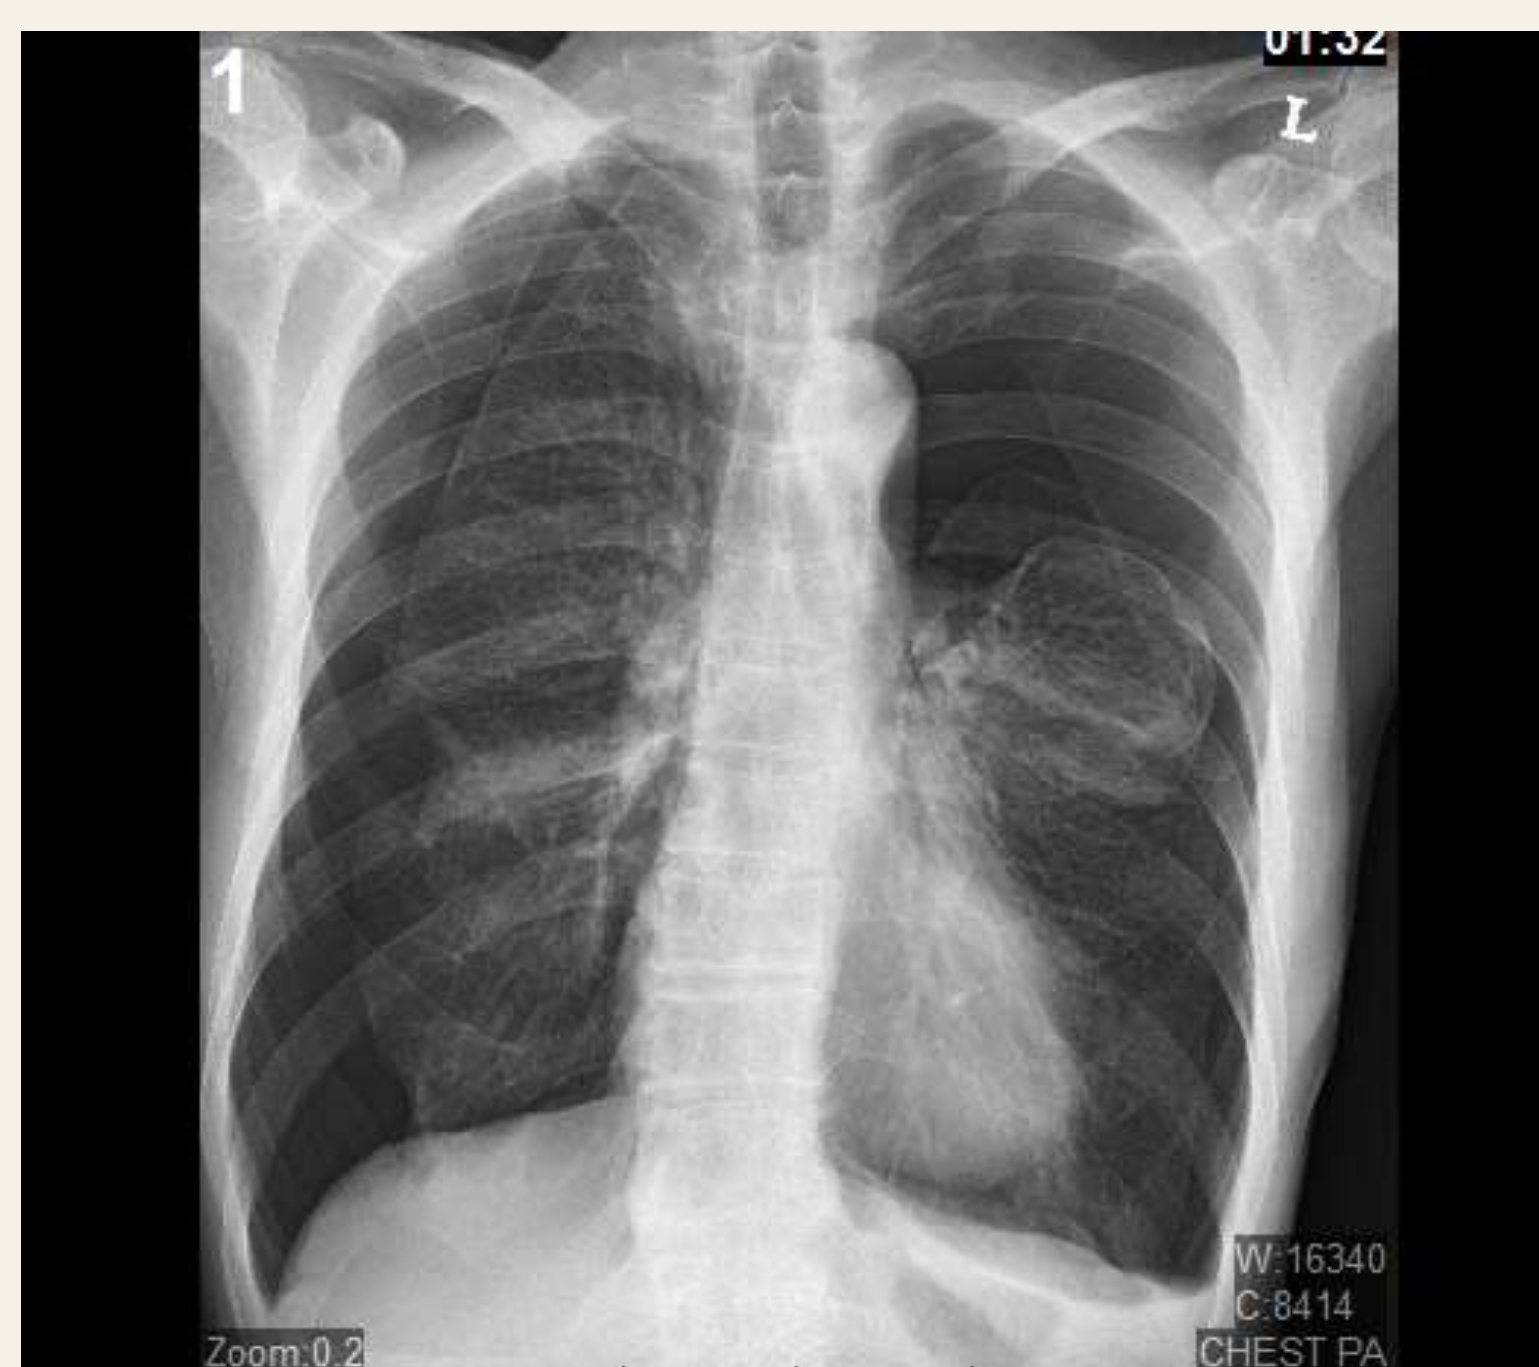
Chest Xray pre chest tube insertion
